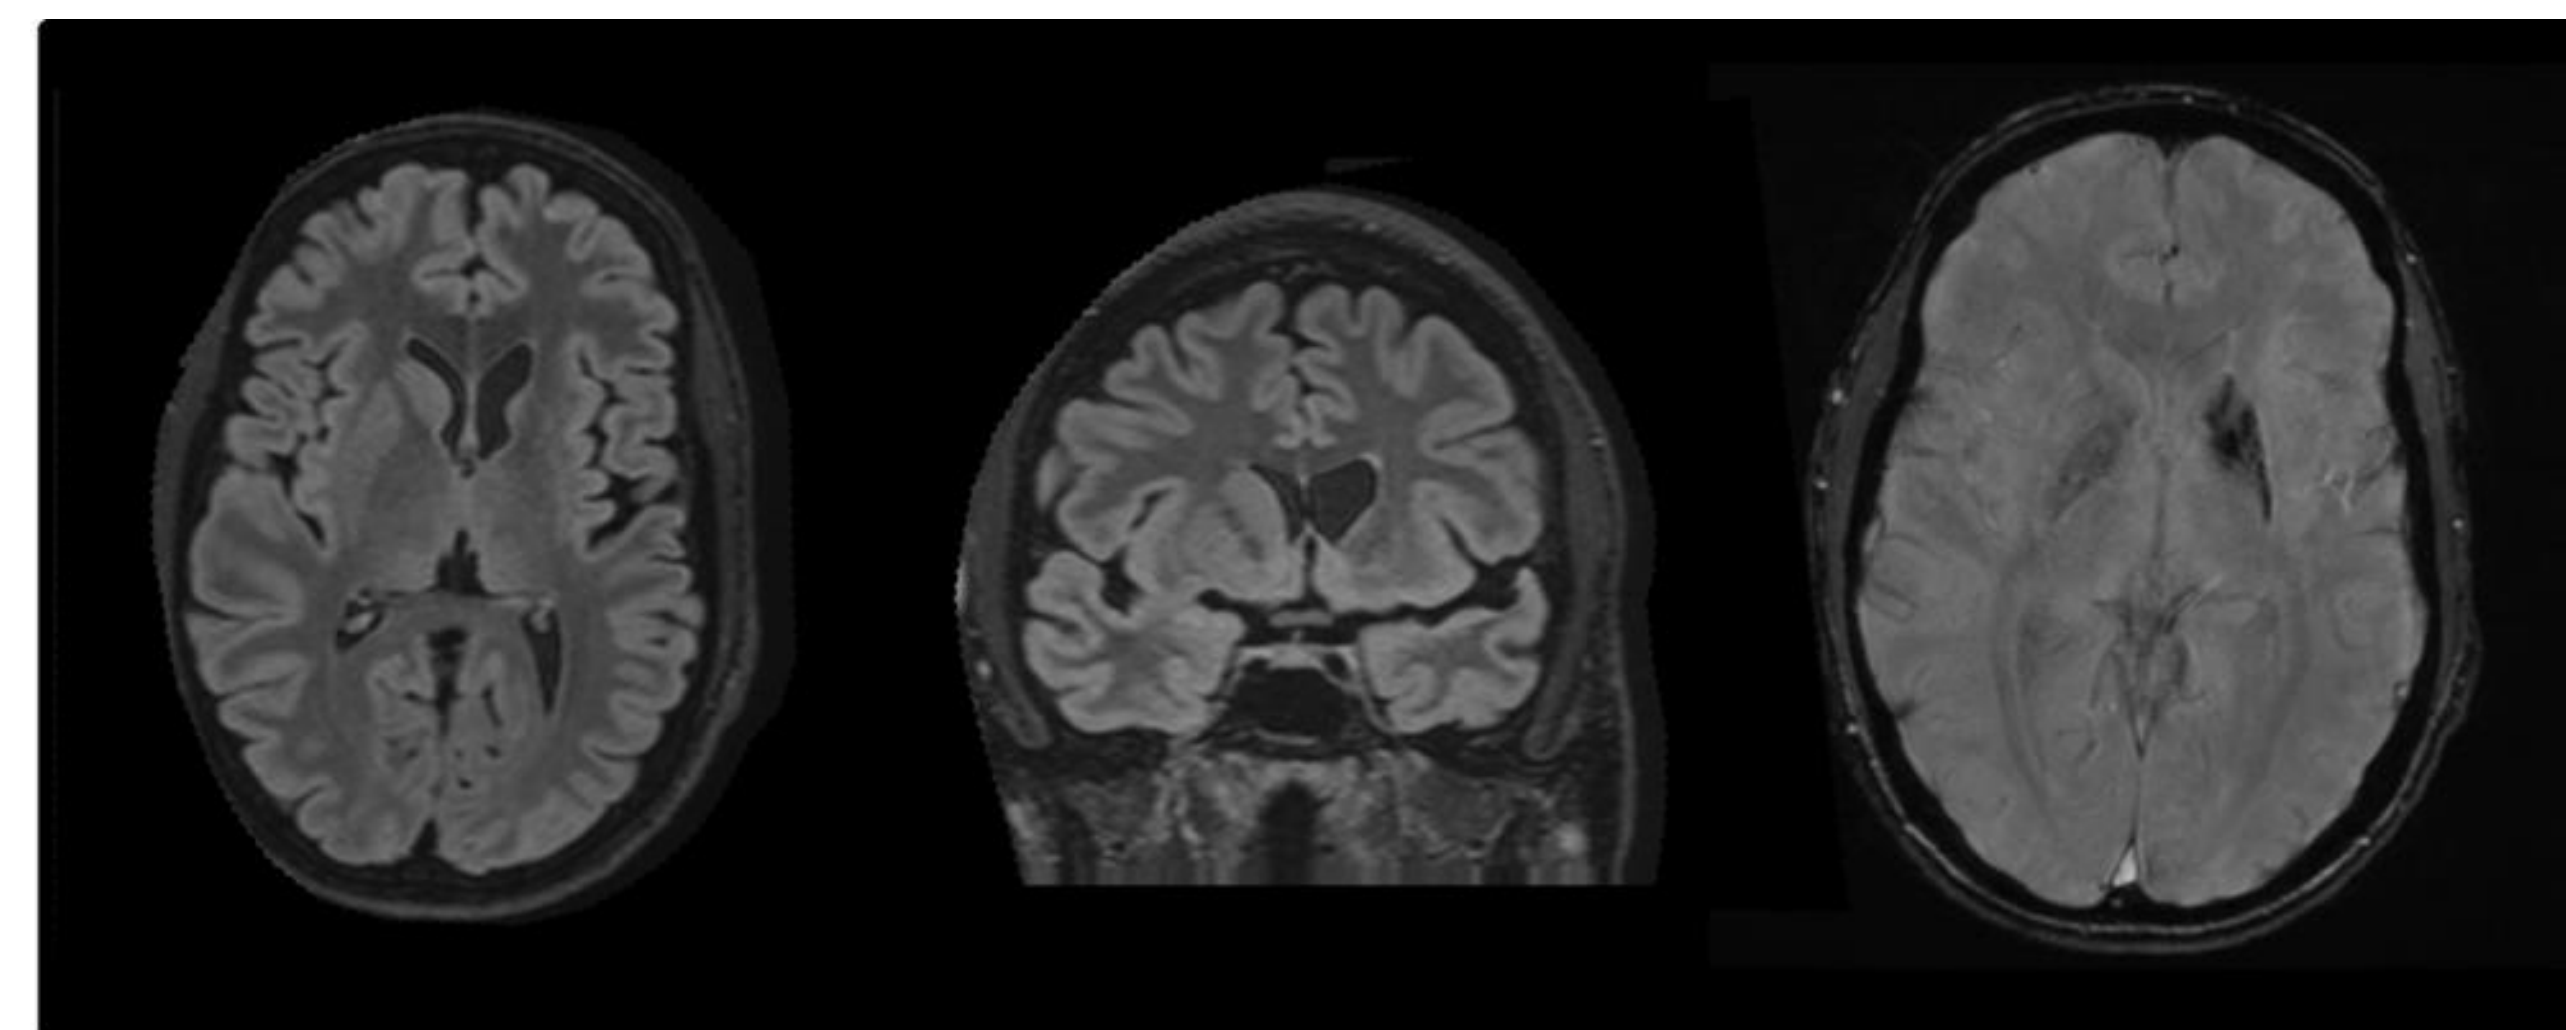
Panel A, from left to right: Axial FLAIR-T2 MRI, Axial SWI MRI - Panel B: DatScan
